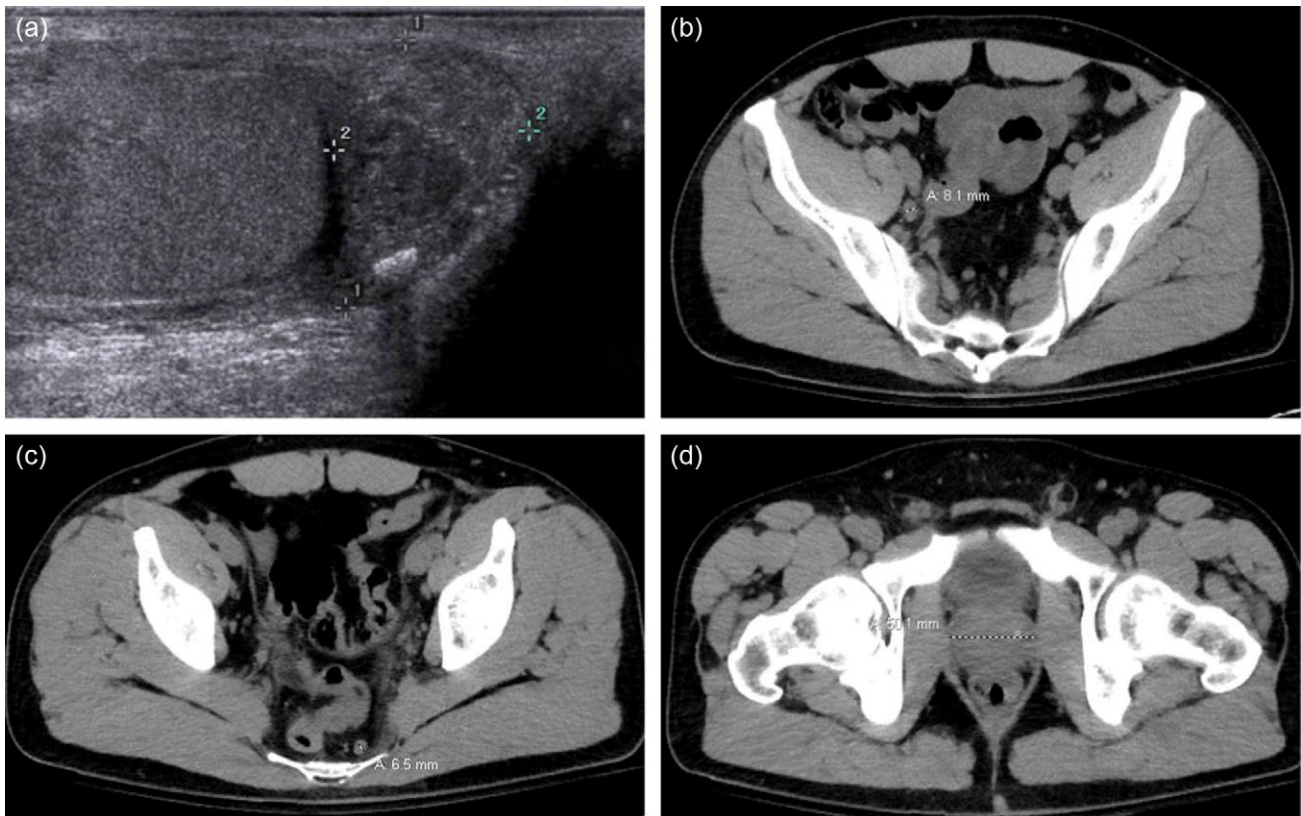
Ultrasound of the scrotum with Doppler revealed a prominent epididymis with increased vascularity in addition to a small left hydrocele. Sonographic findings were consistent with a left epididymitis and an associated left hydrocele (a). CT of the abdomen/pelvis without contrast was performed revealing left-sided peri-ureteral fat stranding, a prominent left seminal vesicle, with infiltrative fat stranding predominantly centered around the left hemi-pelvis with multiple prominent pelvic lymph nodes up to 8.1 mm within the right iliac chain including prominent inguinal lymph nodes up to 6.5 mm (b and c). The prostate is top-normal in size at 5 cm (d). Sonographic findings were consistent with inflammatory changes within the left hemi-pelvis with prominence of the left seminal vesicle and prostate favored to be secondary to prostatitis.
